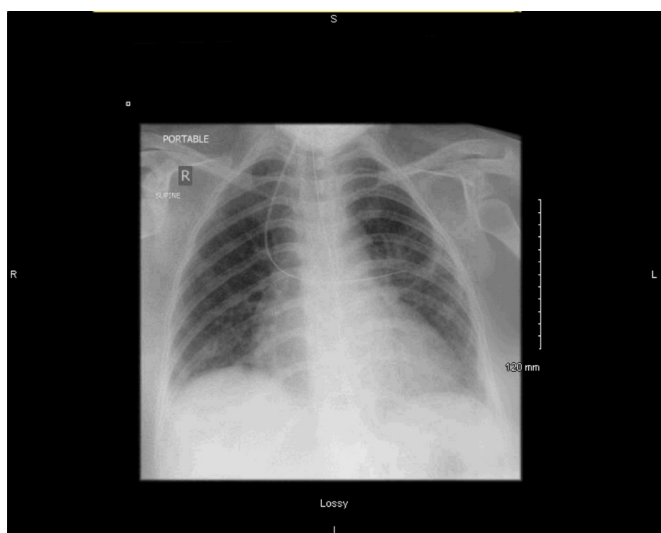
Anteroposterior chest x-ray prior to discharge from hospital showing improvement in bilateral consolidation
